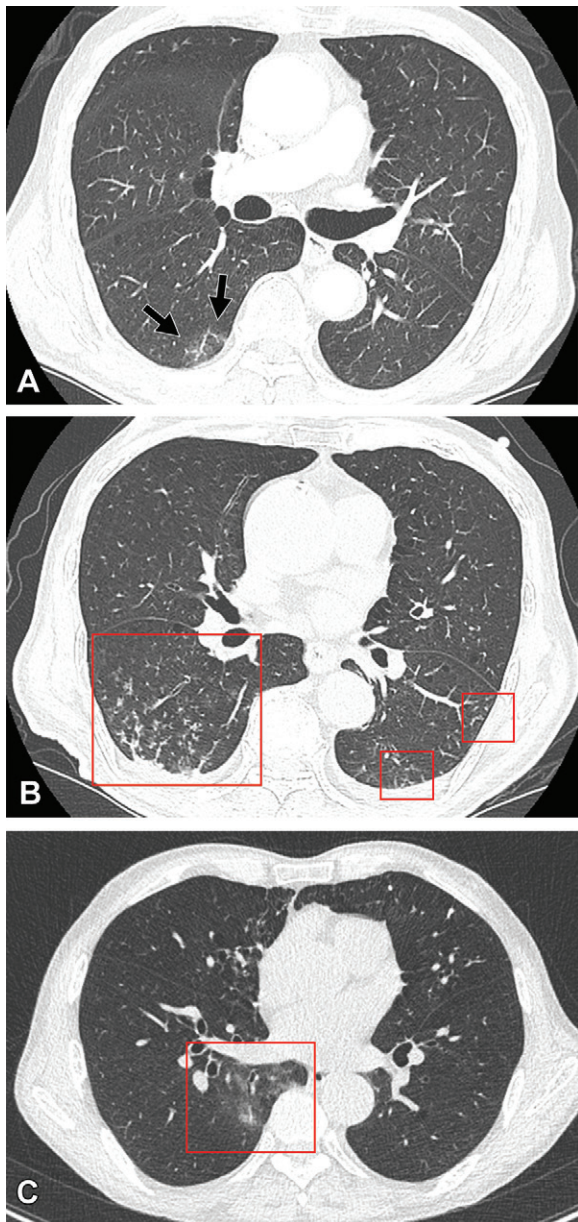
Cases of SARS-CoV-2 reinfection and breakthrough infection during an Omicron BA.5 subvariant–predominant period. (A, B) CT scans (lung window) in an 82-year-old man with COVID-19 reinfection during an Omicron BA.5 subvariant predominant period. The patient had a history of prior Omicron BA.1 subvariant infection and cerebrovascular accident. (A) Transverse nonenhanced CT scan obtained at bronchus intermedius level at the time of Omicron BA.1 subvariant (his first infection) shows focal area of ground-glass opacity (GGO) in superior segment of right lower lobe (arrows). CT findings were classified as “indeterminate” according to the RSNA chest CT classification system. (B) Transverse nonenhanced CT scan obtained at the level of basal trunks at the time of reinfection of Omicron BA.5 subvariant 4 months after the first infection shows poorly defined centrilobular nodules in the dependent portions of bilateral lower lobes (squares). CT findings were classified as “atypical” according to the RSNA chest CT classification system. (C) CT scan (lung window) of breakthrough infection of SARS-CoV-2 during an Omicron BA.1 subvariant–dominant period in a 76-year-old man with a history of hypertension and pulmonary tuberculosis who had received his COVID-19 booster. Transverse nonenhanced CT scan obtained at level of inferior pulmonary vein shows focal area of poorly defined GGO (square) in the right lower lobe. CT findings were classified as “indeterminate” according to the RSNA chest CT classification system.
